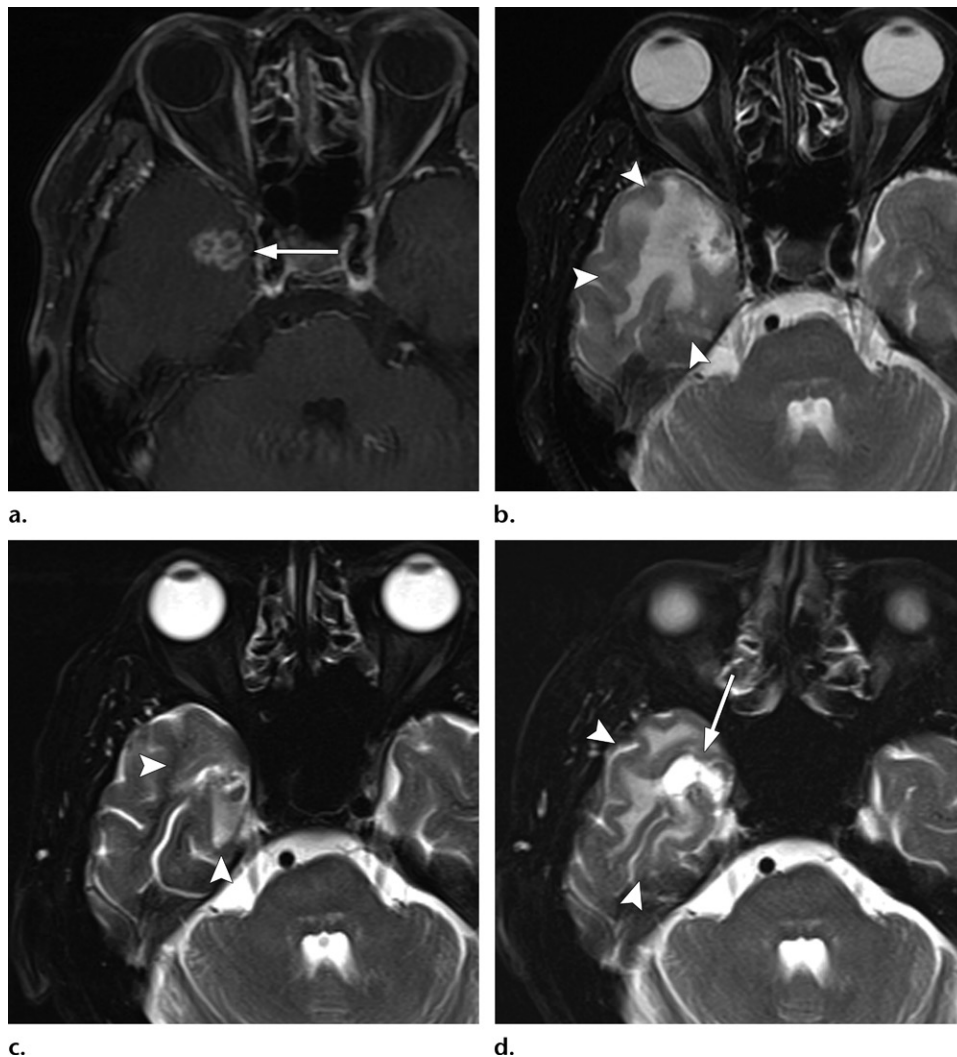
Radiation necrosis in a 57-year-old man who underwent RT (standard-fractionation type) for right-sided nasopharyngeal cancer. (a) Axial contrast-enhanced T1-weighted image 5 years after RT shows enhancing foci (arrow) in the right temporal lobe. (b) Axial fat-saturated T2-weighted image 5 years after RT shows white matter hyperintensity (arrowheads) surrounding the enhancing lesion. (c) Axial fat-saturated T2-weighted image 7 years after RT shows spontaneous regression of the hyperintense white matter lesions (arrowheads). (d) Axial fat-saturated T2-weighted image 9 years after RT shows cyst formation (arrow) with increased white matter hyperintensity (arrowheads).
